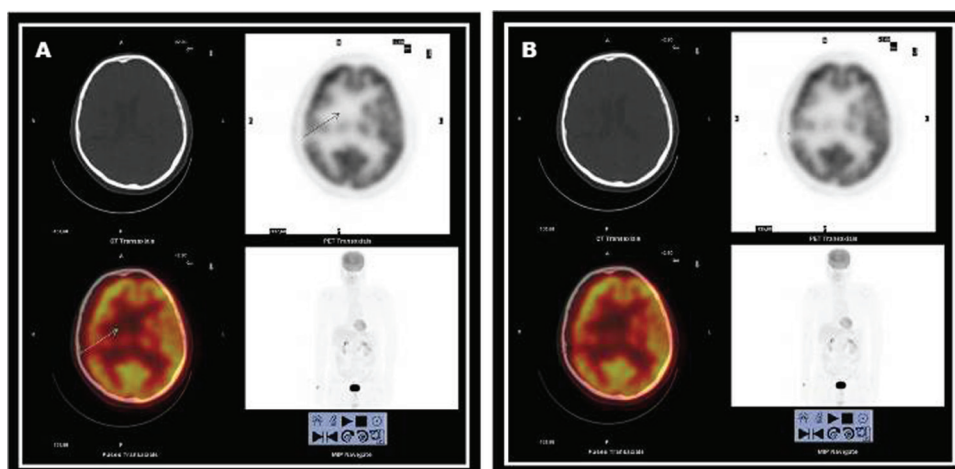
(A,B) Transaxial PET, CT and fusion images and maximum intensity projection images from brain.
